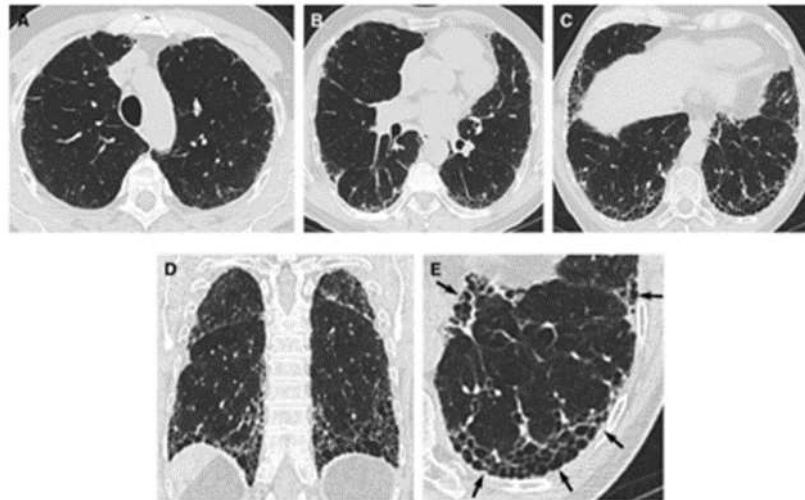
HRCT radiological pattern of UIP. (A-C) Transverse and (D) coronal CT images honeycombing with subpleural and basal predominance. (E) A magnified view of the left lower lobe shows typical characteristics honeycomb, consisting of clustered cystic air spaces with clear walls and variable diameter accompanied by opacity ground glass light.
